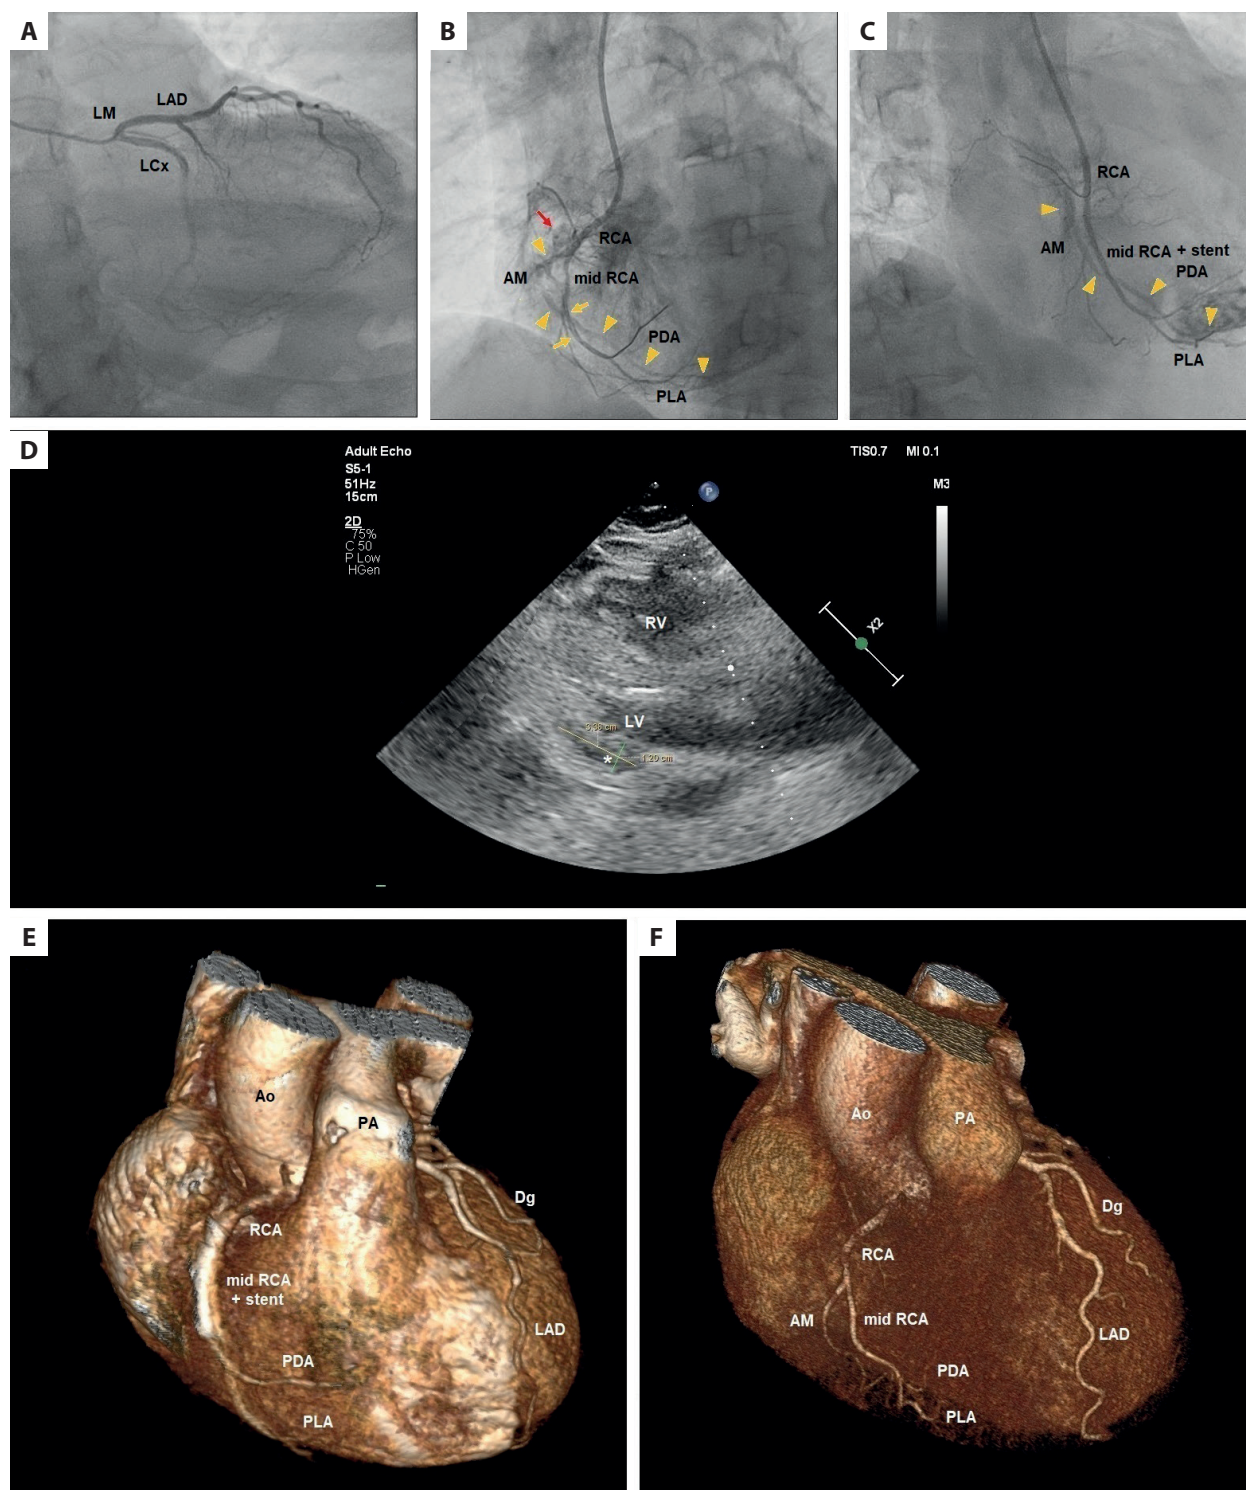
A–C. Invasive coronary angiography and percutaneous coronary intervention. A. Non-obstructive lesions in the left main coronary, left anterior descending, and left circumflex arteries. B. A lesion in the right coronary artery bifurcated into the mid-right coronary artery, and a crashed acute marginal branch (arrowheads) filled retrogradely from the collateral circulation from the posterolateral artery. Coronary angiogram before angioplasty showed dissection in the mid-right coronary artery (yellow arrows) and blush along the acute marginal branch with contrast jet extravasation (red arrow). C. The crashed acute marginal branch (arrowheads) was inaccessible with a guide wire. D. Transthoracic echocardiography, parasternal long axis showing intramyocardial dissecting hematoma (asterisk) 3 days after percutaneous coronary intervention, dimeters: 34 × 12 mm. E. 3D VR cardiac computed tomography angiography (64 thick) performed 3 days after percutaneous coronary intervention confirmed total occlusion of the crashed artery. F. 3D VR cardiac computed tomography angiography (128 thick) performed 1 year before the accident demonstrated high bifurcation of the right coronary artery into the mid-right coronary artery and the acute marginal branch with non-obstructive lesions
